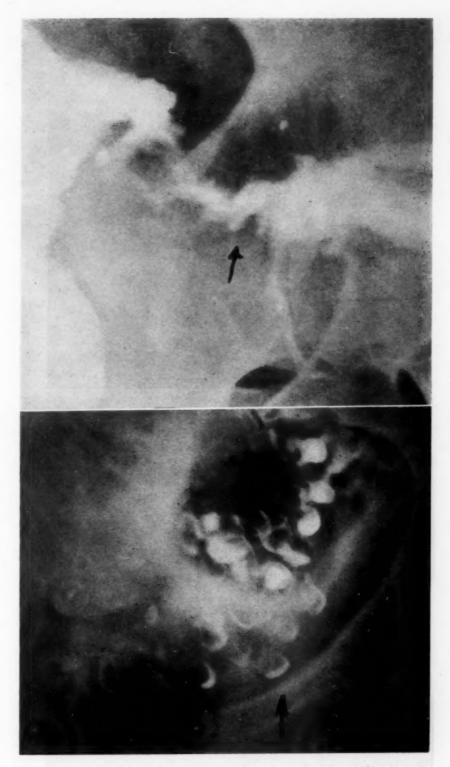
(top) Persistence of obstructive lesion 21 months after colostomy. (bottom) Extreme diverticulosis of descending colon and sigmoid obscuring carcinoma of rectosigmoid, demonstrated by roentgen-ray and proctoscopy.
